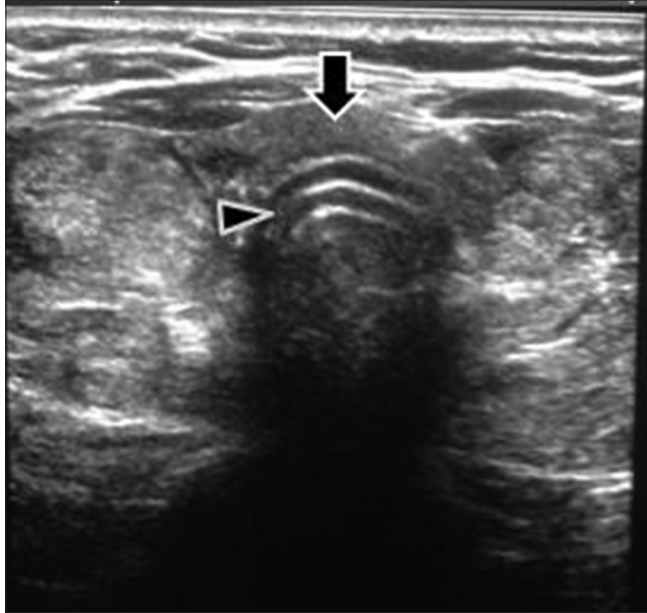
High-resolution sonography at mid neck level on transverse section shows enlarged thyroid with isthmus (arrow) overlying the trachea (arrow head) and multiple echogenic nodules in both lobes
